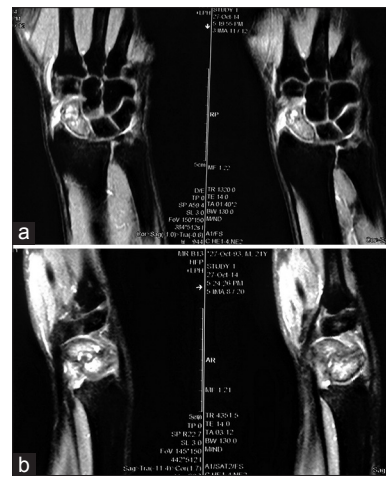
The magnetic resonance imaging showing marrow edema and destruction of scaphoid and surrounding extensive soft-tissue edema in T1 coronal (a) and sagittal views (b)
